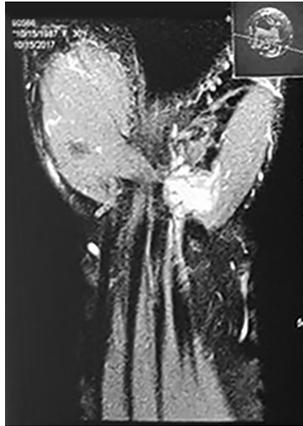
Coronal cut on T2 MRI obtained from the patients right upper limb shows a solid hetero/homogenous soft tissue mass (4×5 mm) at the Guyon canal within the hypothenar muscle. The radiology report described a tumor with low T1 and T2 signal and moderate enhancement.
